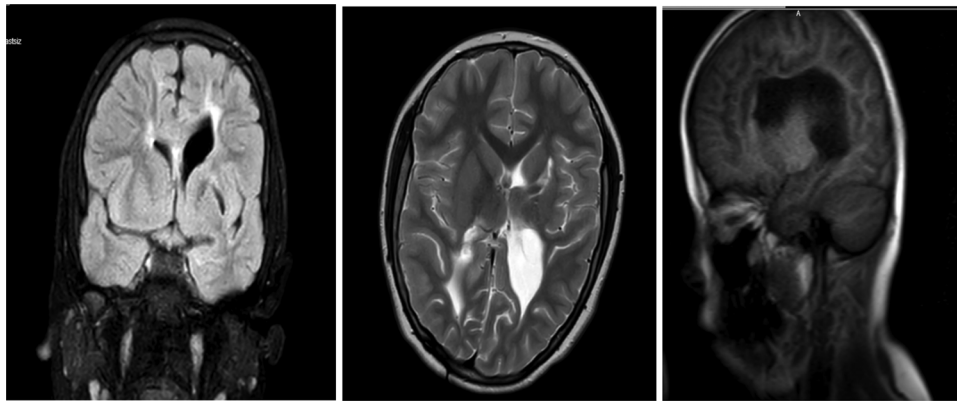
Cranial MRI revealed a widespread gliotic signal increase in white matter, marked atrophy in the right lateral ventricle compared to the left; a hydroptic appearance in the left lateral ventricle, particularly in the occipital horn; and corpus callosum dysgenesis.
